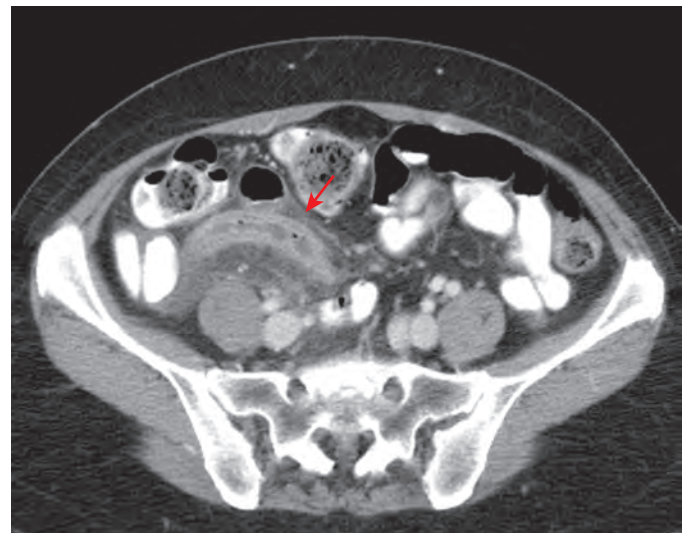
Appendicitis: CT features. Axial image shows a dilated, fluid- and gas-filled appendix (arrow), with mural thickening and periappendiceal inflammatory changes.
